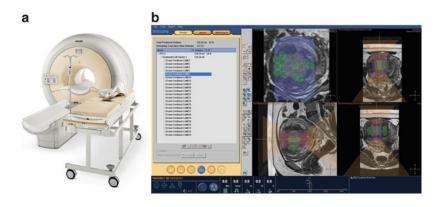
Philips Sonalleve's high-intensity focused ultrasound ablation. (a) Philips HIFU tabletop adjacent to standard scanner table for MRI-guided ablation. (b) The user interface is computer based, providing sophisticated image-based planning, dosimetry, and monitoring. In the planning mode shown, multiple sonications are
